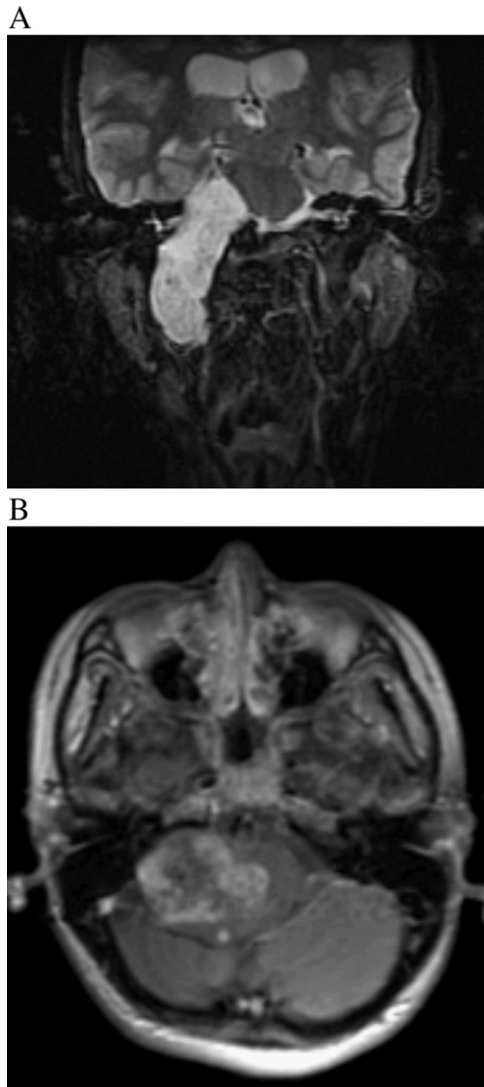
Preoperative T2-weighted coronal (A) and contrast-enhanced T1-weighted axial (B) MRI scans show a tumor in the right cerebellopontine angle, causing medial displacement of the medulla, with dumbbell-shaped extracranial extension to the parapharyngeal space through the enlarged hypoglossal canal.
